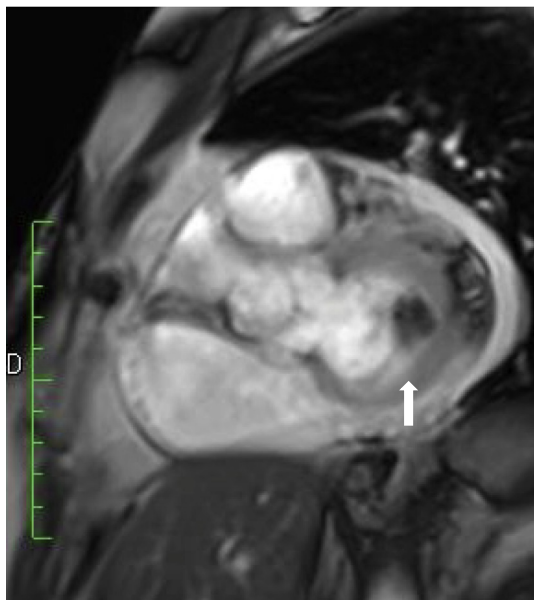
Basal short axis cine image shows hypointense round mass-like lesion (arrows). Delayed postcontrast cardiac magnetic resonance image shows peripheral enhancement (arrow).
